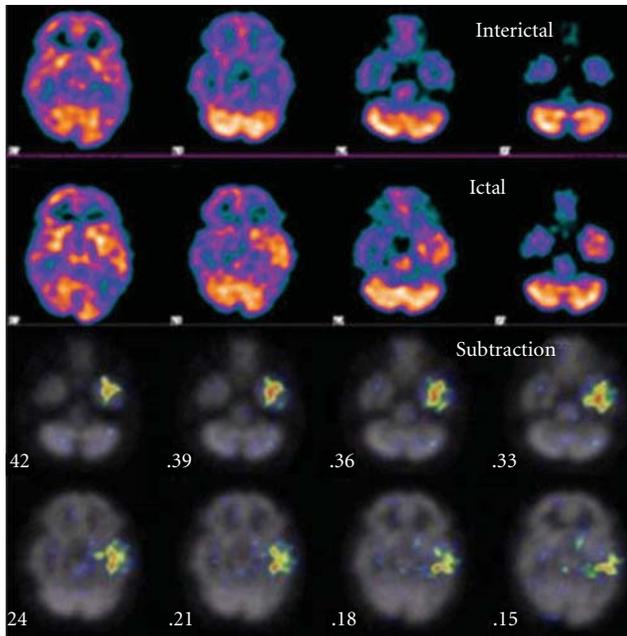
An interictal technetium-99m ECD brain SPECT scan (top) as compared with an ictal technetium-99m ECD brain SPECT scan (second row). On the ictal brain SPECT scan one can see increased hyperemia involving the left temporal lobe (third and fourth rows). Using subtraction comparison, one can see statistically significant differences between the ictal and interictal scan involving the left temporal lobe. The test for statistical significance has z values between three and four (red color = z value of 4).
